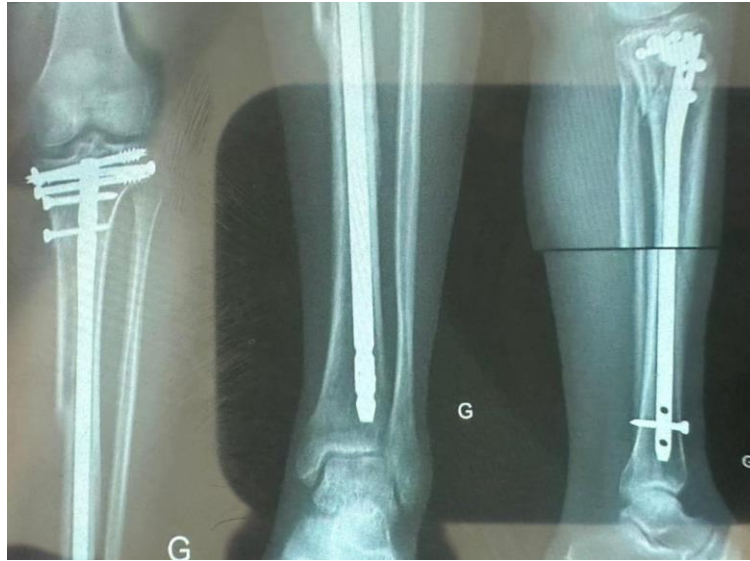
Radiographic control at six months showing progressive union, maintained alignment and no implant breakage
